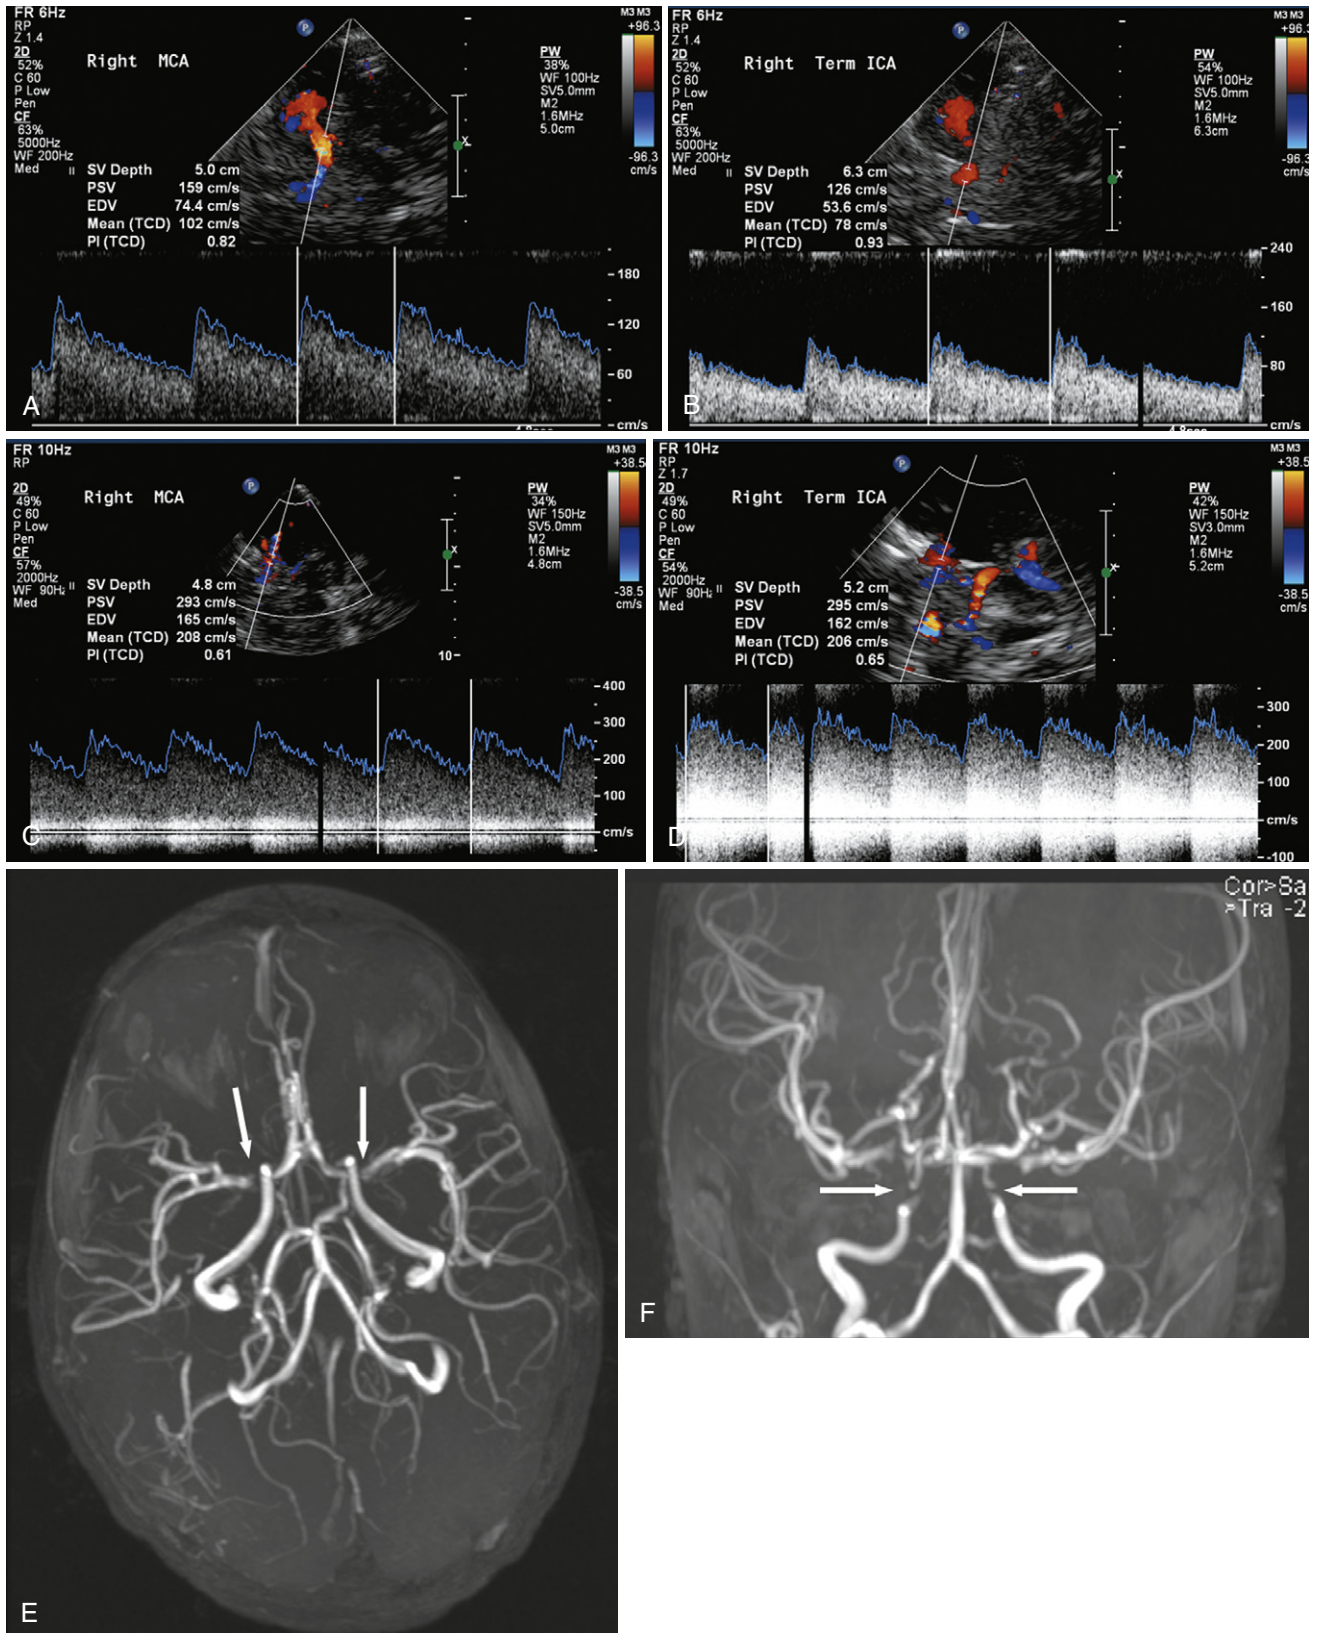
Transcranial Doppler ultrasound images. Color and spectral Doppler waveforms from (A) normal right MCA and (B) right terminal ICA. Abnormal right middle cerebral (C) and terminal internal carotid (D) waveforms in another patient with sickle cell disease and prior history of stroke. MR angiographic images (E and F) of this patient with abnormal Transcranial Doppler demonstrate narrowed proximal MCAs and terminal ICAs.
